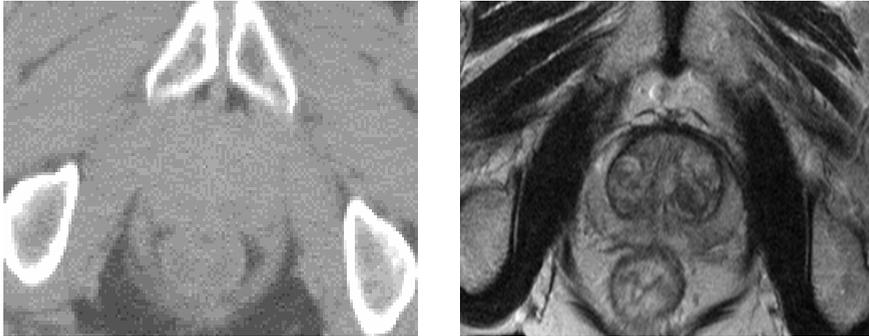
Differences in soft tissue contrast on a) computed tomography (CT) and b) magnetic resonance imaging (MRI) of the prostate.
